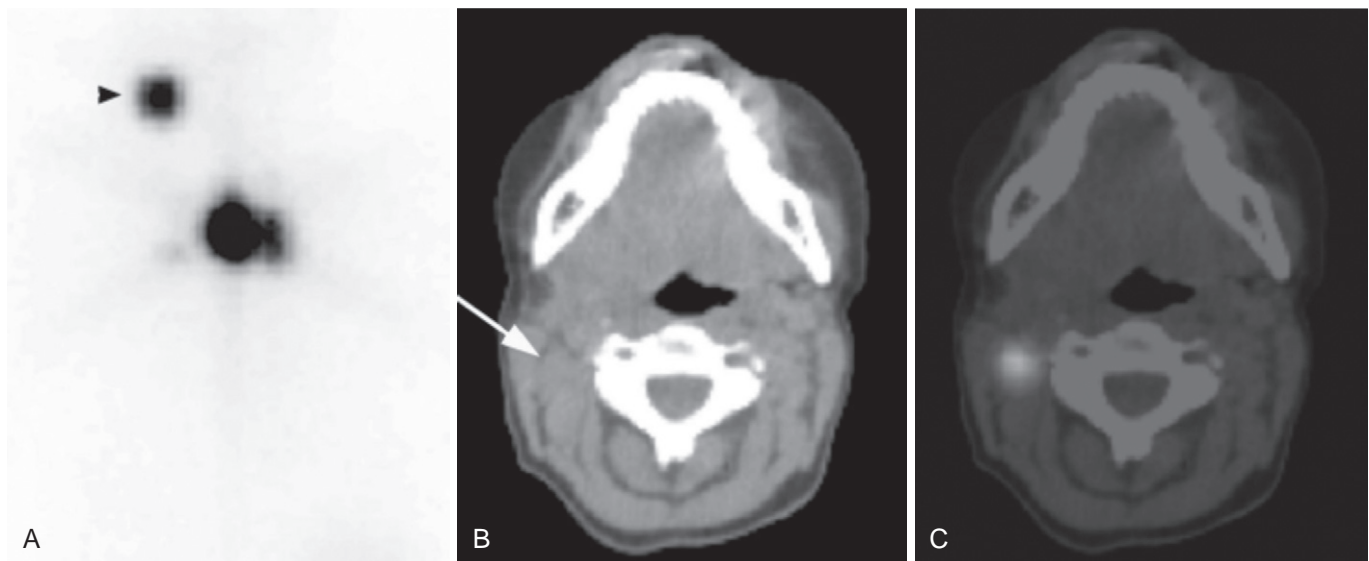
SPECT/CT for nodal localization: cervical nodal metastasis in a 12-year-old girl. A, Planar image shows a single focus in the right upper neck (arrowhead) and two foci of activity in the central neck. B and C, Computed tomography (CT) and fused single-photon emission computed tomography (SPECT)/CT localizes the right upper neck focus to an enlarged lymph node (arrow). (Reprinted from Wong KK, Zarzhevsky N, Cahill JM, et al: Hybrid SPECT-CT and PET-CT imaging of differentiated thyroid cancer. *Br J Radiol* 2009;82:860-876, 2009; with permission from the British Journal of Radiology.)
